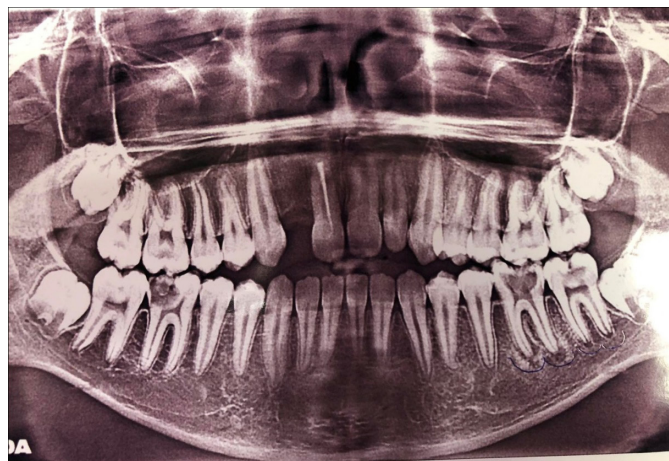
Orthopantomogram of the patient at the initial visit
